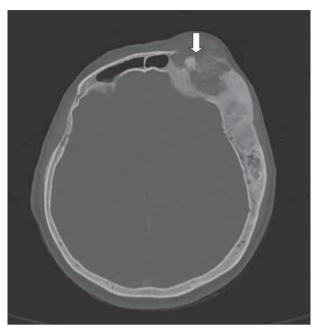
Computed tomography showing fibrous dysplasia with the area of cortical destruction (arrow).
